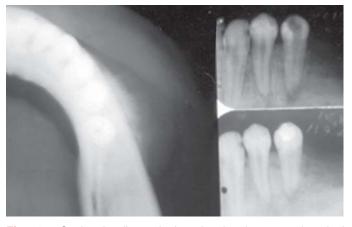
Occlusal radiograph view showing the external cortical portion with radiopacity similar to 'sunrays' and increased periapical space of the premolar tooth seen in osteosarcoma
